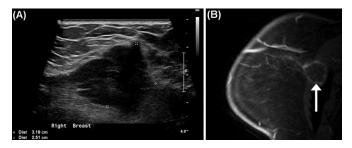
A: Sonogram showing a heterogeneously hypoechoic mass. B: Sagittal magnetic resonance imaging (MRI) reveals a predominantly T2 hyperintense mass (arrow) with rim enhancement involving the pectoralis muscle.
